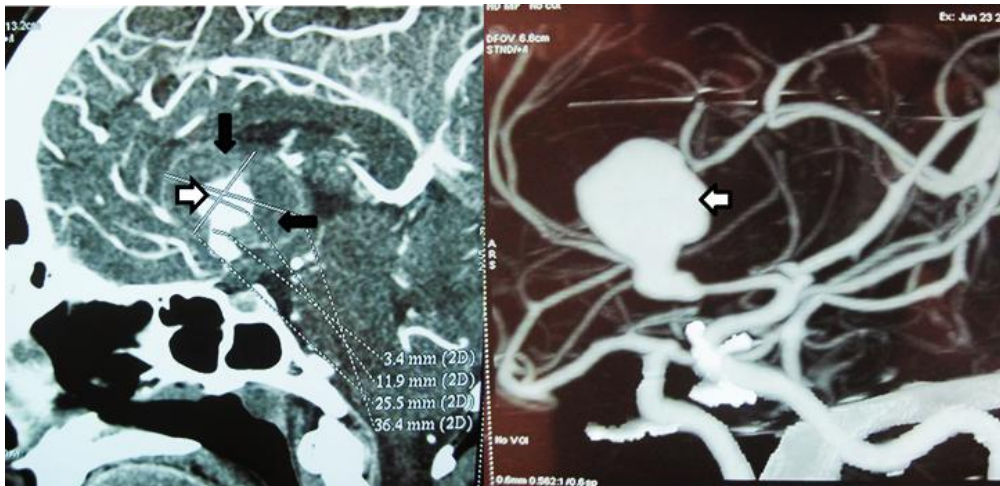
CT angiography – a giant aneurysm of the anterior communicating artery that causes hydrocephalus:
